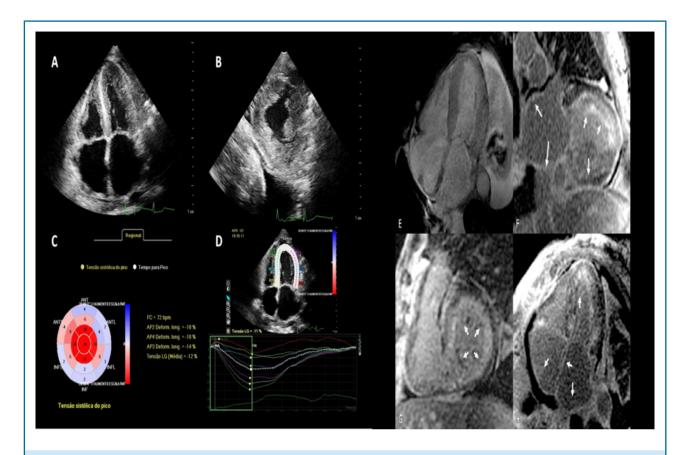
(A) Apical four-chamber view showing biatrial enlargement, thickened interatrial septum, left ventricular wall hypertrophy, with hyperechoic texture of the myocardium. (B) Parasternal short axis view. Concentric left ventricular hypertrophy. (C) Bullseyes. Global longitudinal systolic strain (mean value of (-)12%), with prominent basal and medium impairment, and preserved apical mechanical function. (D) Apical four-chamber strain showing that the ratio between the apical inferior septal strain and the lower basal septal strain is greater than 3. (E) Cine-mode of the stationary state free precession showing diffuse left ventricular myocardial thickening. (F) Long axis post-gadolinium image showing diffuse late improvements (arrows) in the left atrium, as well as subendocardial enlargement of the left ventricle, more prominent in the anterior wall. (G) Short axis postgadolinium image showing diffuse subendocardial enhancement (arrows) in the left ventricle. (H) Four-chamber post-gadolinium image showing late enhancement (arrows) not only in the left chambers, but also of the right atrium.
